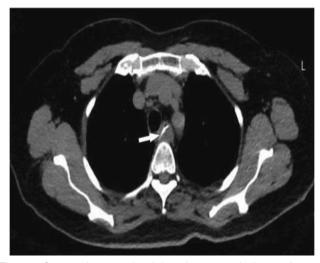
Computed tomography of chest demonstrated 1 linear radiopaque lesion over the upper-third of esophagus (arrow), indicating foreign body impaction.
